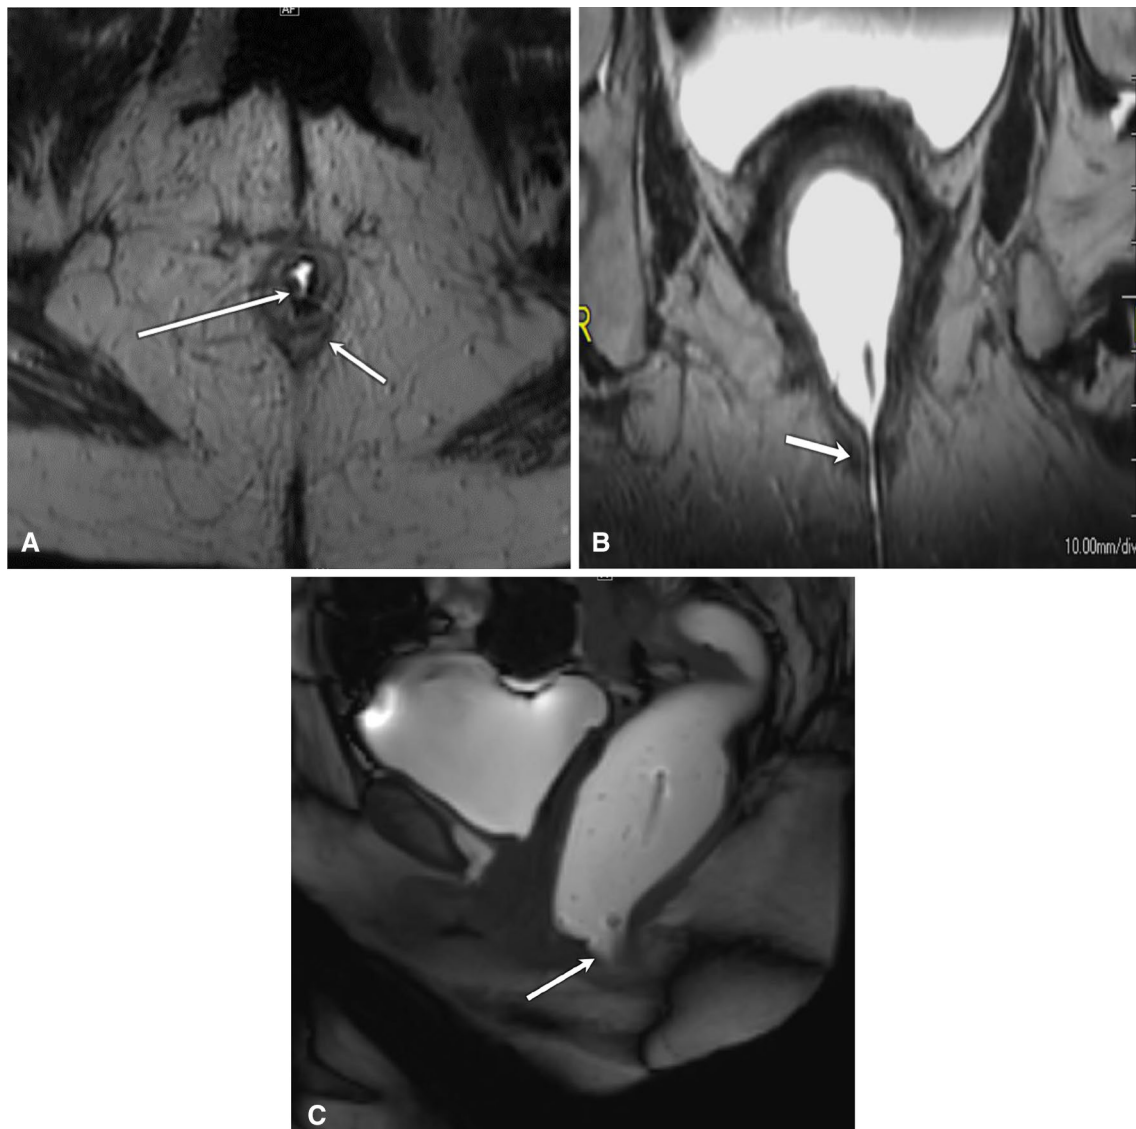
Fecal Incontinence. Axial-oblique through the axis of the anal canal high resolution T2-weighted image. a Shows atrophied internal anal (long arrow) and external anal sphincter (short arrow). Coronal-oblique through the axis of anal canal T2 weighted image. b
